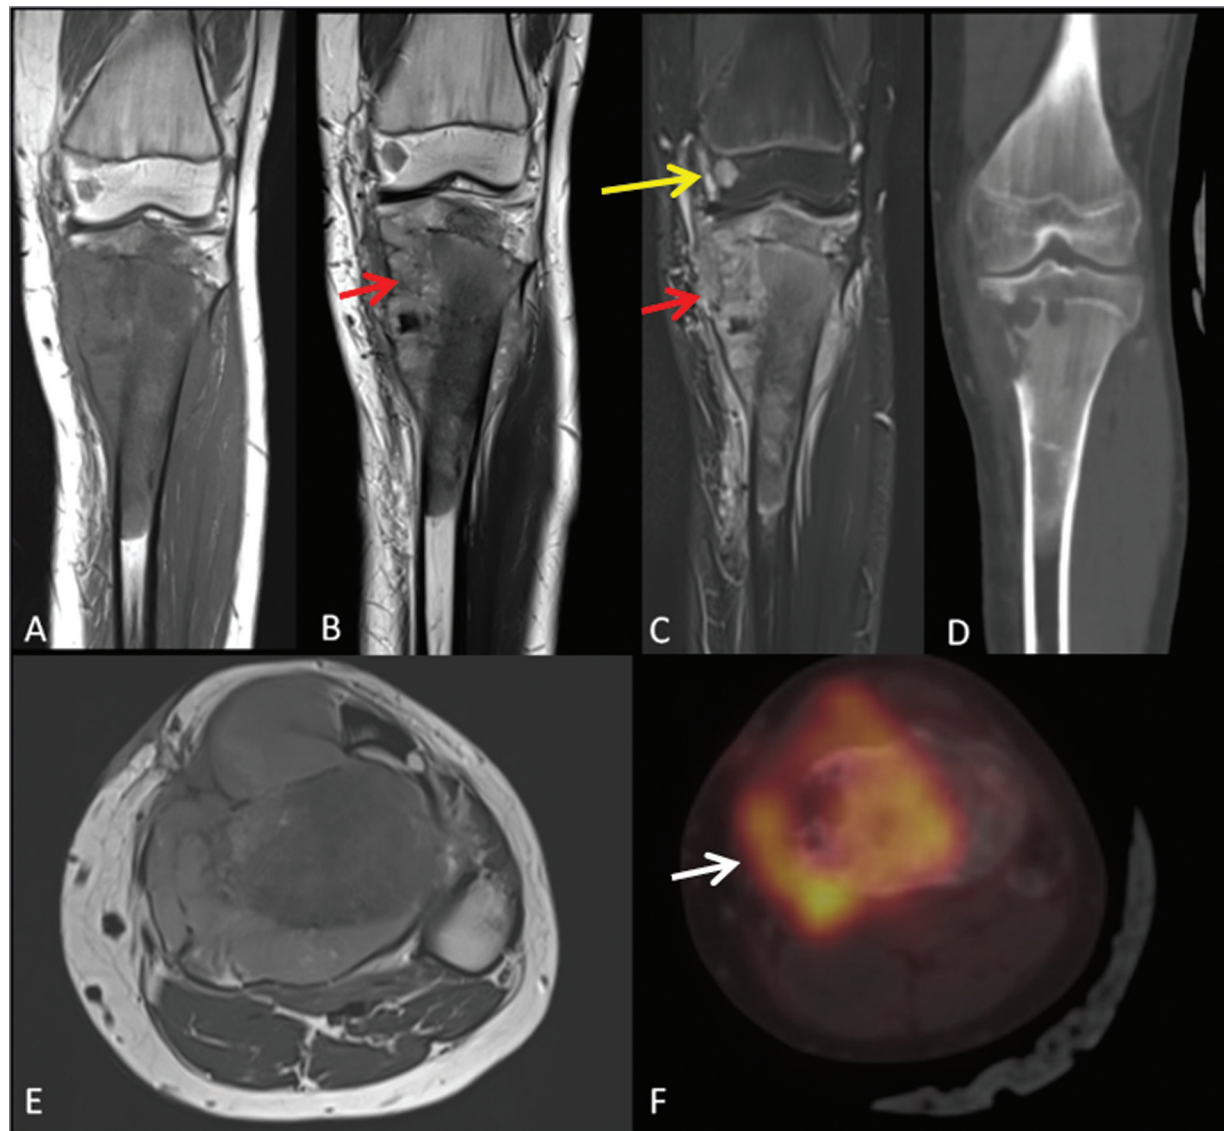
Coronal T1 MRI (A), T2 MRI images (B), Coronal STIR (C) Coronal CT (D) and axial T2 MRI (E) images reveals heterogeneous hyperintense lytic lesion (red arrows) involving the epi-metaphysis region with cortical erosions (D) and adjacent metabolically active soft tissue component on (PET-CT) images (white arrows). STIR hyperintense skip lesion (yellow arrows in C)—was also seen in the right medial femoral condyle. Abbreviations- Magnetic resonance imaging (MRI), Position emission tomography-computed tomography (PET-CT), short tau inversion recovery (STIR).
